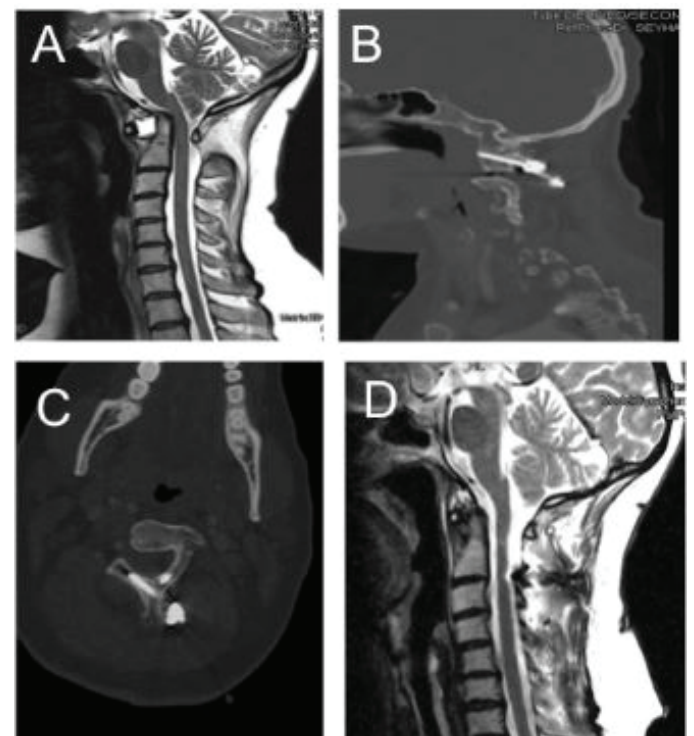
Pre-operative T2-weighted sagittal MRI (A) shows substantial widening of the anterior atlantoaxial joint and basilar invagination producing stenosis of the foramen magnum and mass effect on the cervicomedullary junction. Post-operative sagittal (B) and axial (C) CT and sagittal T2-weighted MRI (D) after Goel procedure show marked reduction in the atlantodental interval and reducing in basilar invagination. Compression on the cervicomedullary junction has been resolved.
